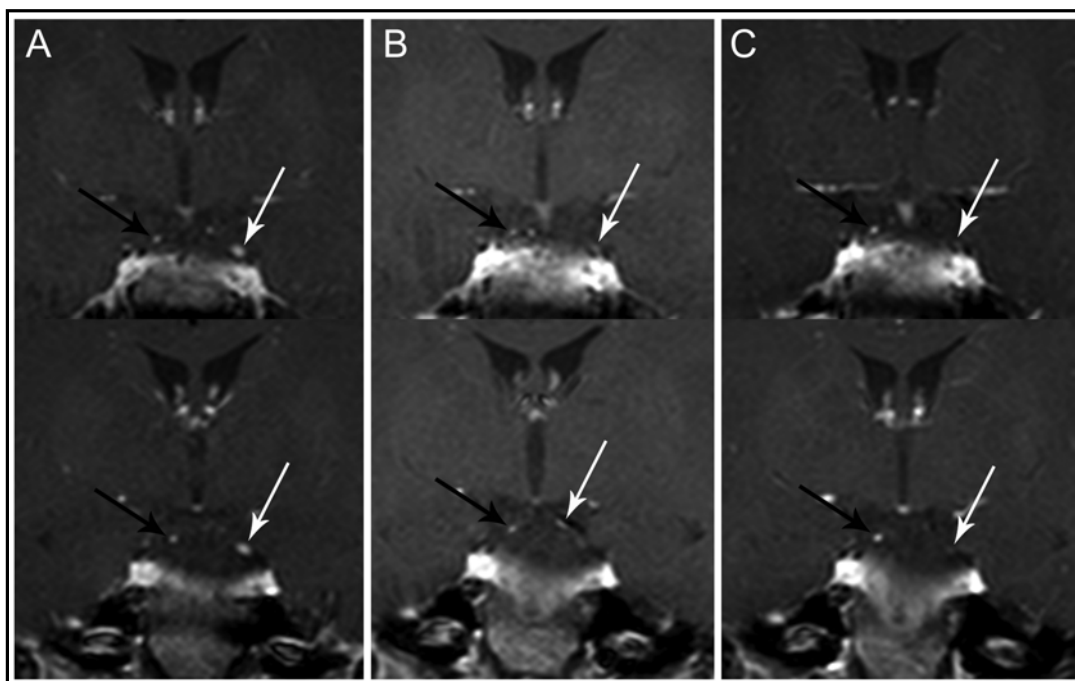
Gadolinium-enhanced T1 coronal magnetic resonance imaging (MRI). (A) The initial MRI. The patient had left oculomotor nerve palsy. The bilateral oculomotor nerves showed high signal intensity, and the density was prominent on the left side. (B) The second MRI which was performed when the patient had right oculomotor nerve palsy. The bilateral oculomotor nerves showed high signal intensity; however, the left oculomotor nerve density had decreased since the initial MRI. (C) The third MRI performed after patient's recurred symptoms were resolved. The left oculomotor nerve enhancement disappeared. The right oculomotor nerve still showed enhancement. White arrows indicate left oculomotor nerve and black arrows indicate right oculomotor nerve.
